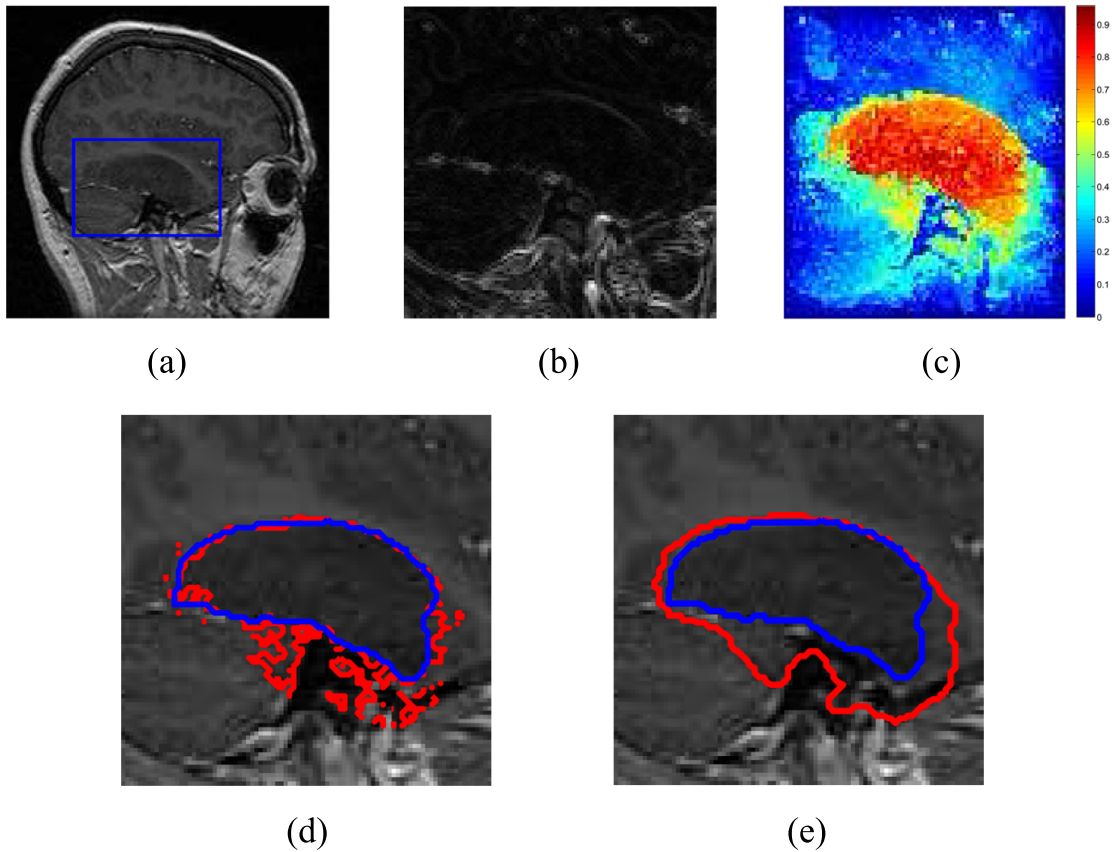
Brain tumor repository data set case 8. (a) MR image slice; (b) gradient magnitudes; (c) the probability map constructed by Eq.(2.16); (d) Tumor-cut result without smoothing (in red), expert segmentation (in blue); (e) Tumor-cut-smoothed shows a spread out isosurface around value 0.5, possibly due to the tumor tissue depicting an intensity level close to its background and complex background with high gradients near the right boundary.
